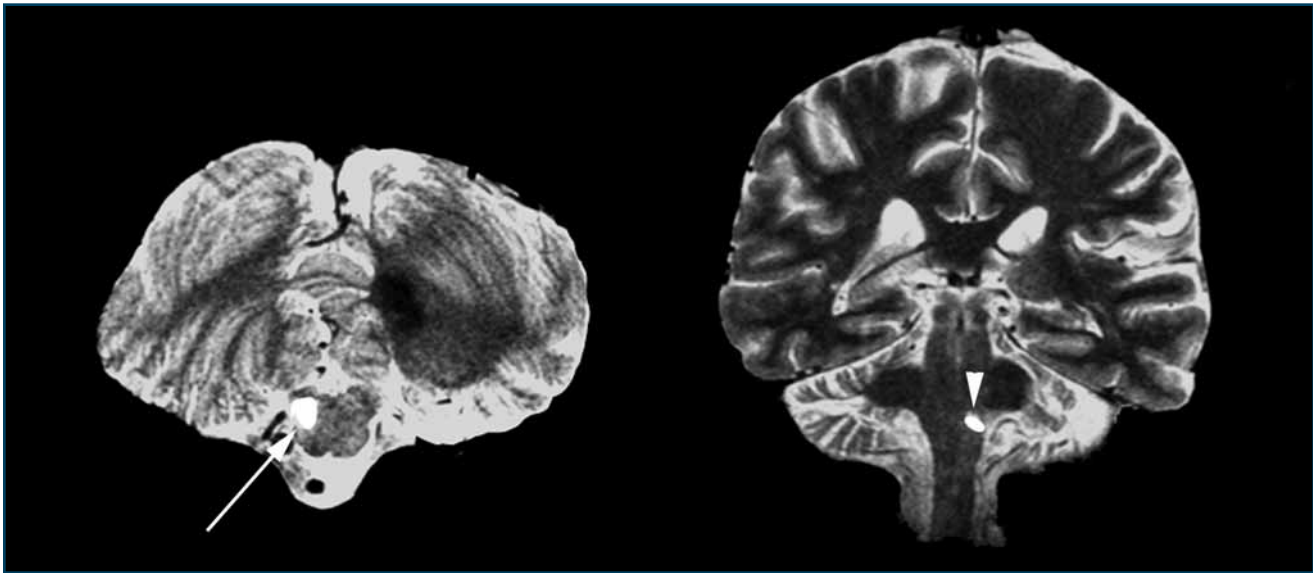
T2-weighted MRI of a patient with Wallenberg syndrome. Left MRI image (transversal plane; *top*: cerebellum; *bottom*: medulla oblongata): On the right side of the medulla oblongata, the hyperintense area corresponds to a typical dorsolateral infarct (*arrow*). Right MRI image (*coronal plane*): The infarction lies in the upper medulla oblongata at the pontomedullar junction (*arrowhead*).
